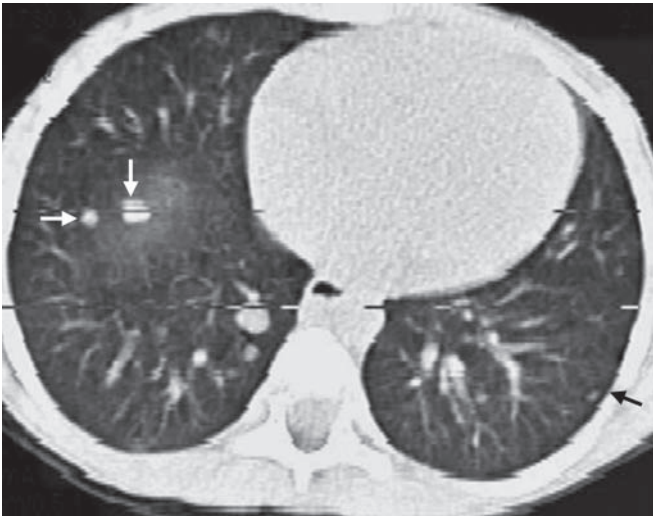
Lung metastases from Wilms' tumour. Axial CT scan through the chest on lung window settings. There are a number of intrapulmonary nodules within both lungs on this image (some of which are arrowed), consistent with intrapulmonary metastases
